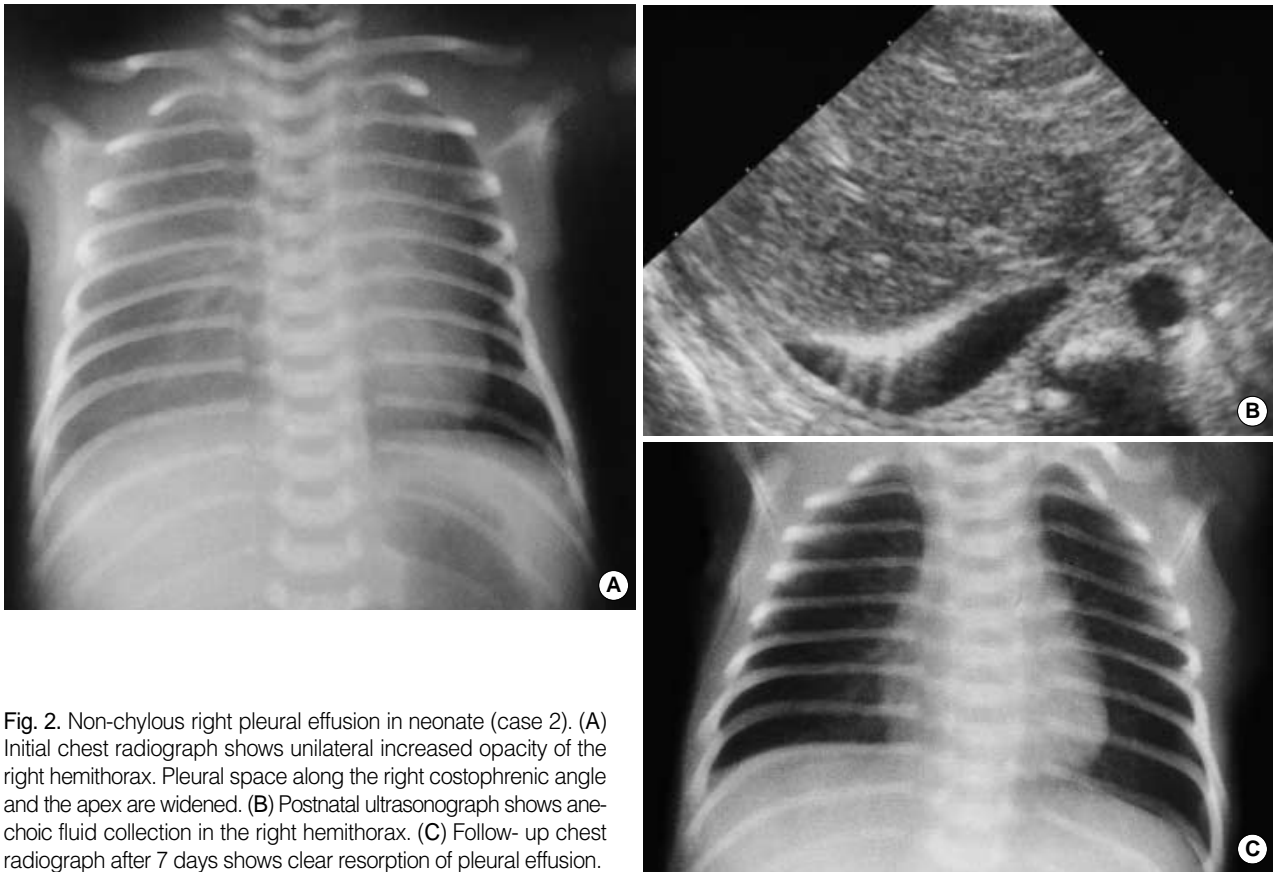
Non-chylous right pleural effusion in neonate (case 2). (A) Initial chest radiograph shows unilateral increased opacity of the right hemithorax. Pleural space along the right costophrenic angle and the apex are widened. (B) Postnatal ultrasonograph shows anechoic fluid collection in the right hemithorax. (C) Follow-up chest radiograph after 7 days shows clear resorption of pleural effusion.
